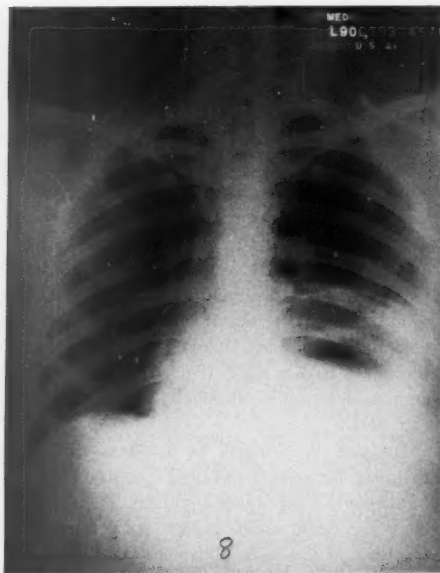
Case 8. Left. Chest x-ray showing air bubble in left thorax with displacement of heart to the right. Right. Barium study confirms stomach displaced upward into chest.
